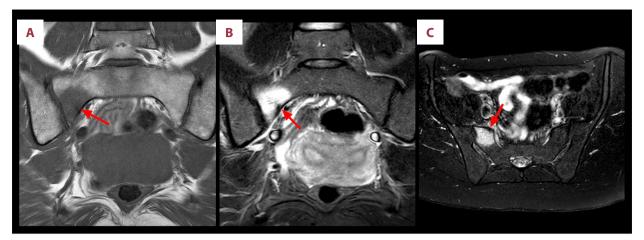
Magnetic resonance imaging (MRI) of the patient's lumbosacral spine at diagnosis of the sacral fracture. (A) T1-weighted, (B) STIR and (C) T2 SPAIR imaging showing focal marrow edema anteriorly (arrows) in the sacrum at the level of S1. Features are consistent with a stress fracture of the right S1 segment.
